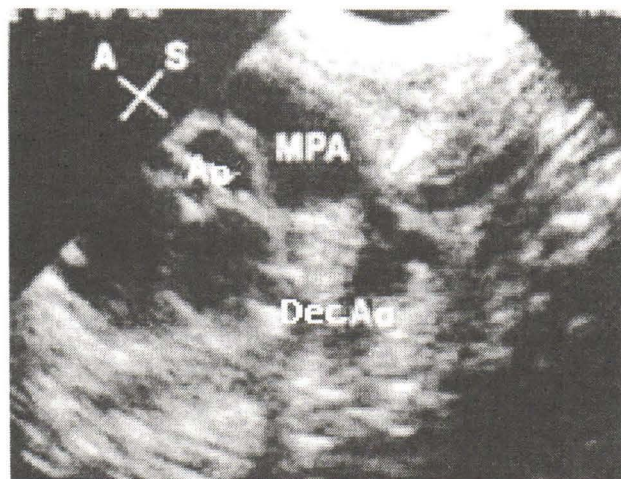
Demonstrates high parasternal or ductal cut view. Arrow points at PDA. A = anterior, S = superior, Ao = aorta, MPA = main pulmonary artery, DecAo = descending aorta.
